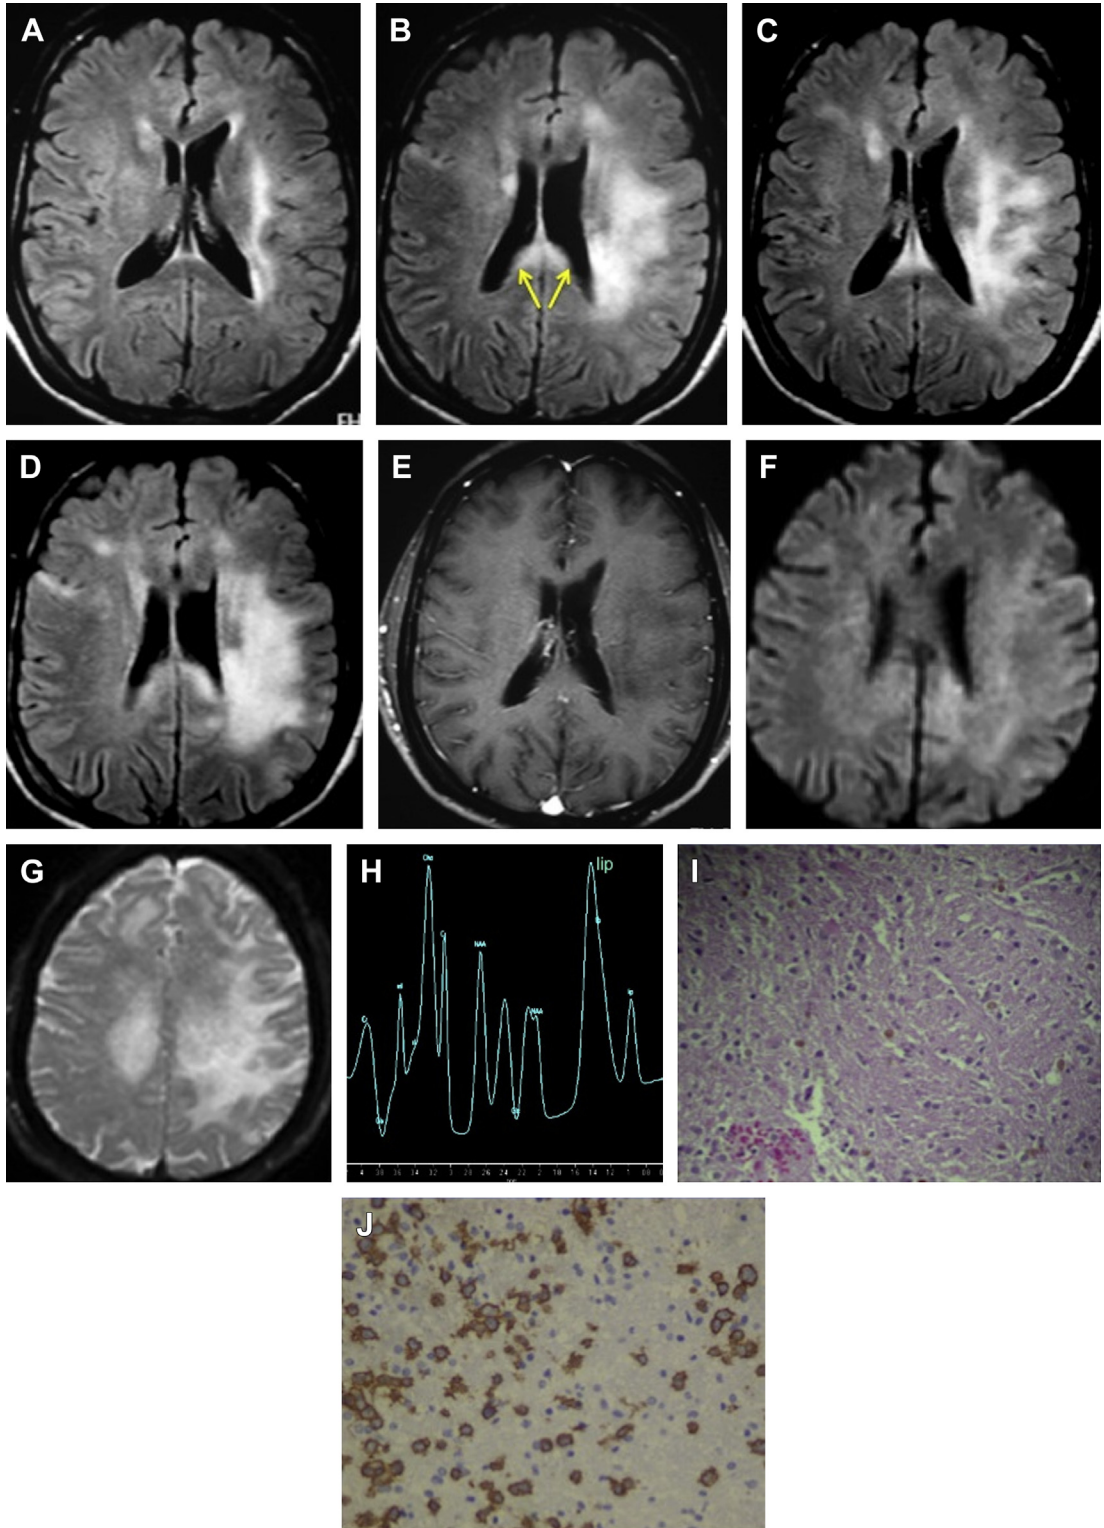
LC. A 40-year-old man with status epilepticus. There is an ill-defined infiltrating lesion in the left frontal and parietal lobes ([A, B] axial FLAIR), extending to the splenium of the corpus callosum ([B] arrows). MR imaging 1 month later ([C, D] axial FLAIR) shows progression. No enhancement is demonstrated ([E] axial T1 with contrast) and there is no restricted diffusion ([F] DWI, [G] ADC map). (H) MRS shows low NAA and ml, high Cho, and lipid peaks, characteristic of LC ([I, J] confirmed at pathology). ADC, apparent diffusion coefficient. (Courtesy of Dr Leonardo Avanza, Vitória, Rio De Janeiro, Brazil; and Leila Chimelli, MD, Rio De Janeiro, Brazil.)
